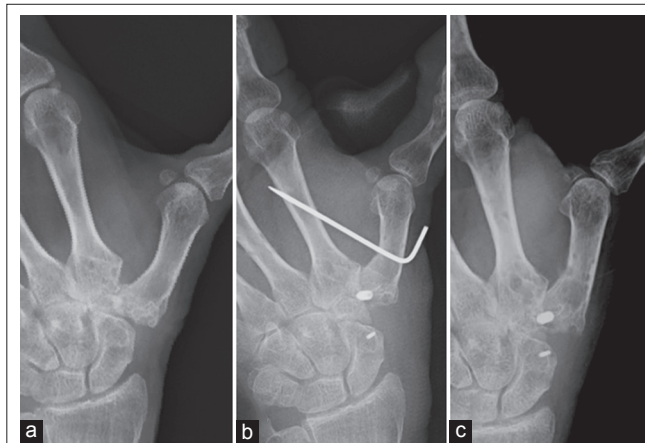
Plain X-ray images taken during the patient's first visit to our clinic (a), just after the suspension arthroplasty and ligament reconstruction operation (b), and 3 years after the operation (c).
